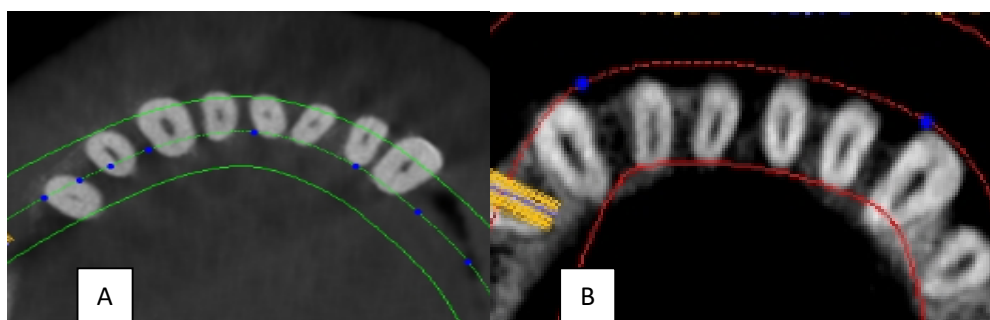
CBCT Images of Mandibular incisors: (A) round type; (B) oval type.
